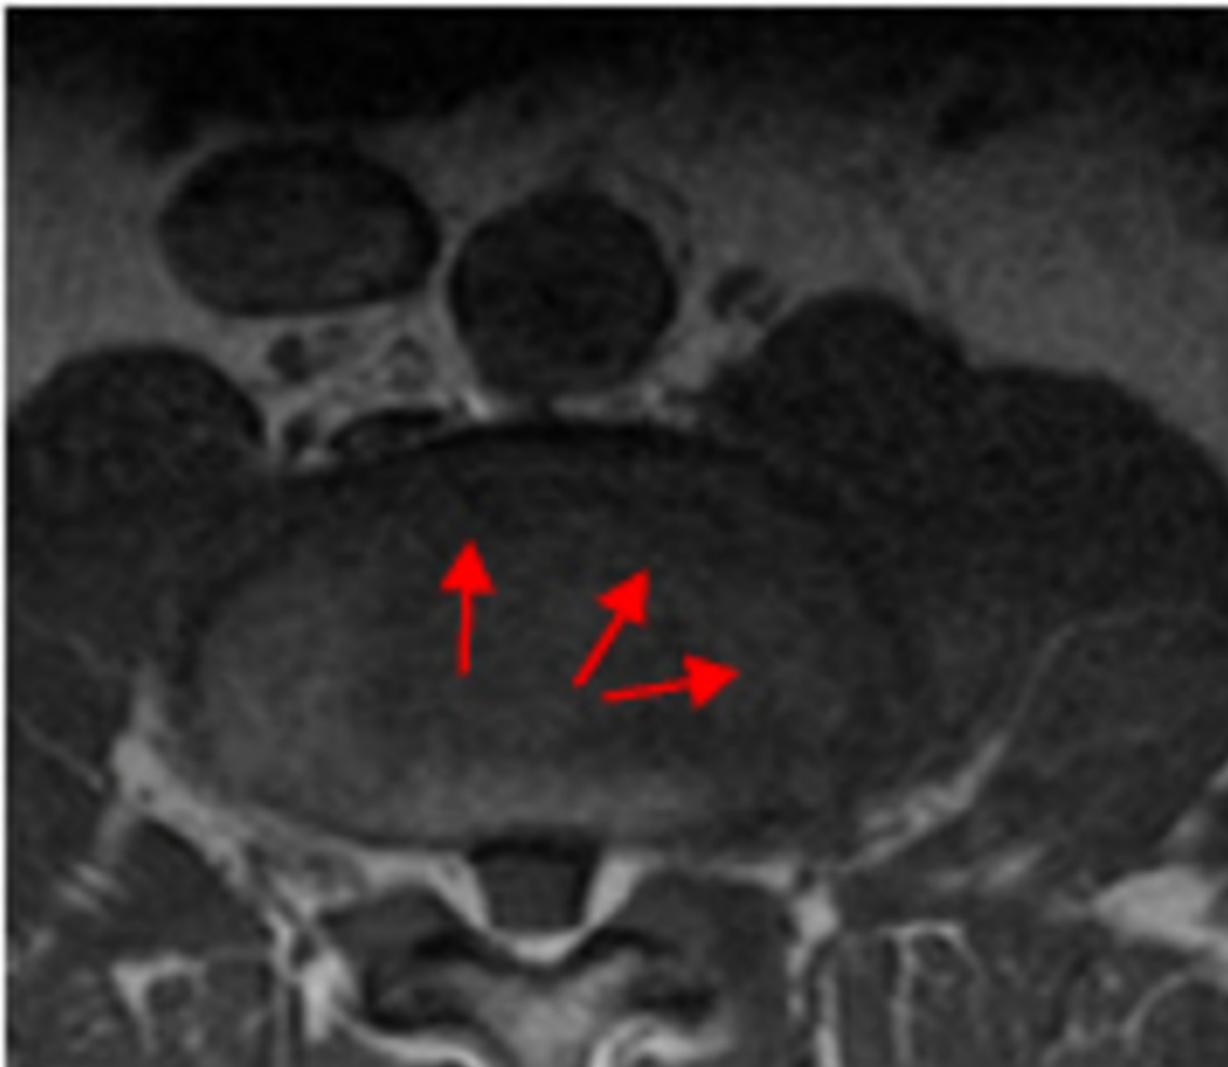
Axial T2 Weighted Lumbar Spine MRI image showing Asymmetrical Disc Bulge (> 50% (180 degree) of disc circumference)
